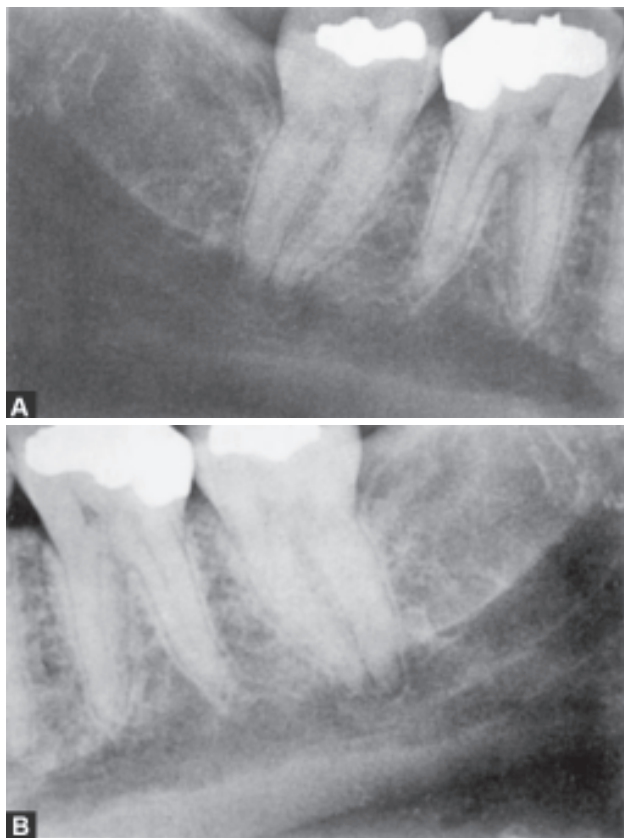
Raised dot on X-ray film and its orientation in film mounts for labial or lingual viewing
